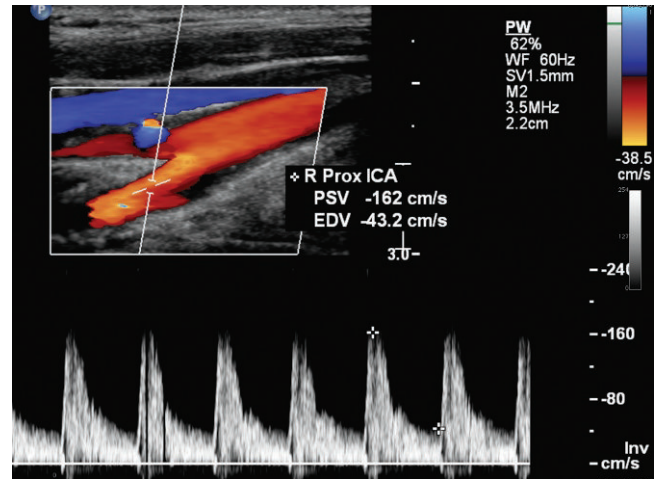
Spectral Doppler of the proximal internal carotid has a peak systolic velocity of 162 cm/s. The internal carotid is widely patent by color Doppler. While there are elevated velocities in the ICA, the velocity is not focally elevated but generally elevated in the carotid circulation. The IC:CC ratio is only 1.16, which does not support a stenosis above 50%. There is mild irregularity at the origin of the internal representing very mild plaque. The generalized increase in velocity was caused by a hyperdynamic state and hyperthyroidism and also explains the neck bruit.
